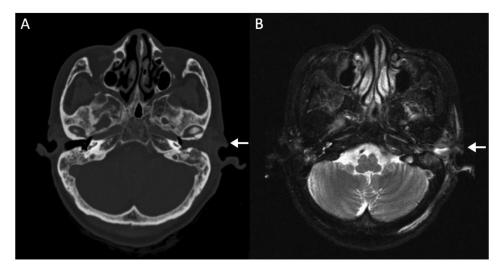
Image finding of patient #6, who was staged as cT3N0M0. (A) In the CT finding, the abnormal soft tissue lesion (arrow) was located in the left EAC with obvious erosion of the mastoid bone in inferior-lateral aspect. (B) In the MRI T2 image, this irregular enhancing mass (arrow) invaded to the left superior parotid gland and to the lateral margin of the left temporomandibular joint.
